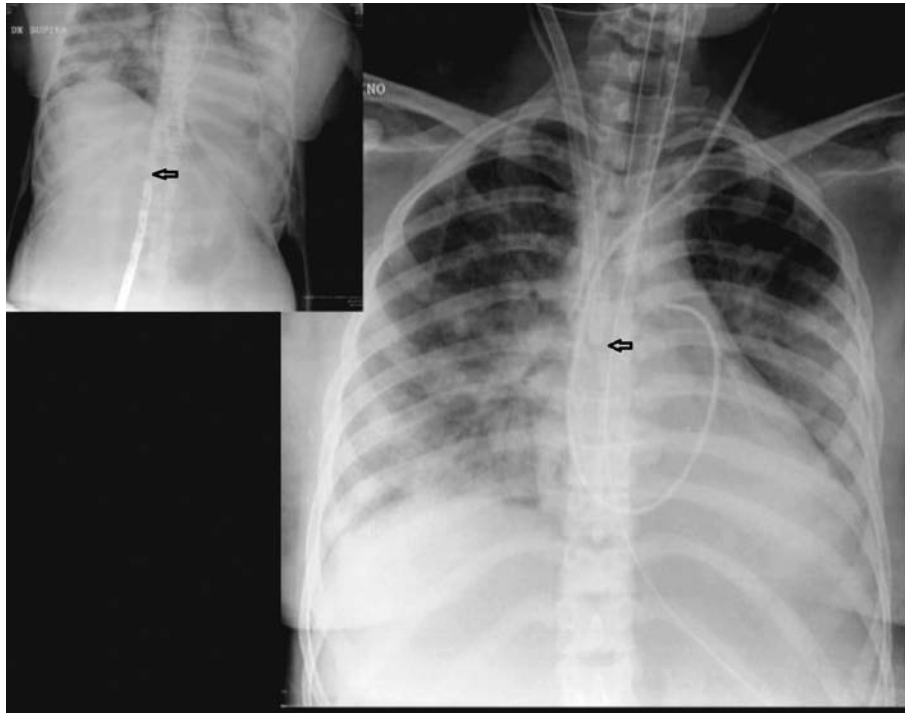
Chest x-ray at admission, showing diffuse, patchy infiltrates in both lungs. Arrows indicate the position of extracorporeal cannulas (in the upper left corner of the tip of the femoral cannula).
